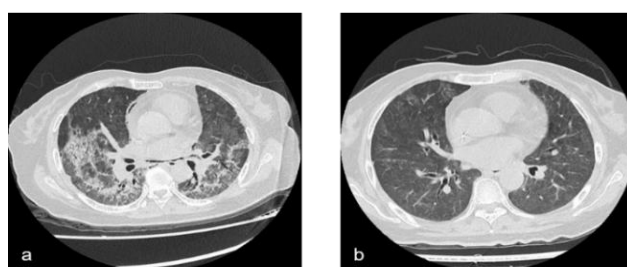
A female patient, aged 55, who presented with newly diagnosed rheumatoid arthritis–interstitial lung disease. (a) HRCT on ICU admission revealed bilateral ground-glass opacification. (b) HRCT showed improvement of bilateral ground-glass opacification after treatment in ICU.
